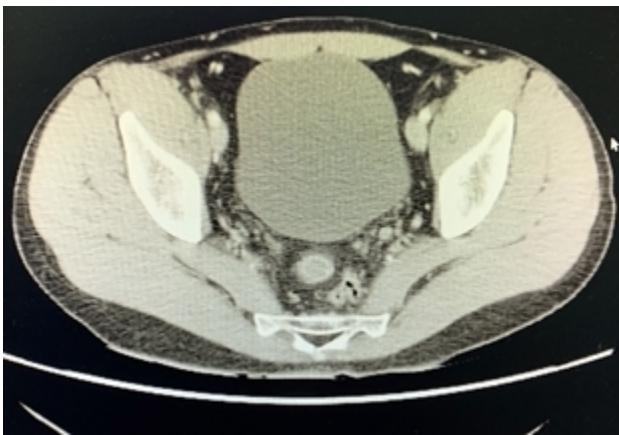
CT of the abdomen showing a small bowel loop with thickened walls in the pelvis and alteration of the adjacent fat.
